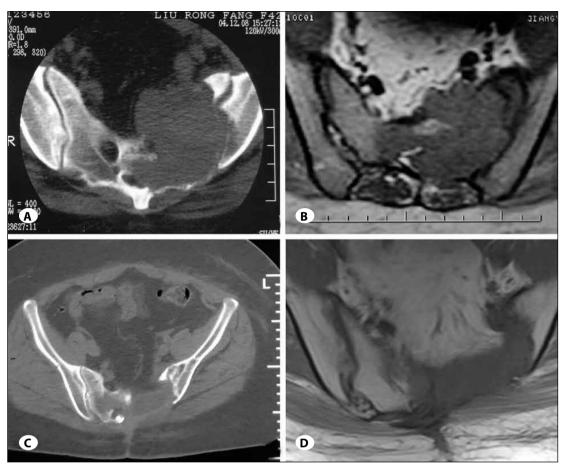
A 41-year-old female who presented with sacral pain and bowel dysfunction. A, B) Axial CT and T1-weighted MRI demonstrated a large destructive mass at the left side of the sacrum; C, D) Axial CT and T1-weighted MRI after the primary operation, no tumor could be observed.
